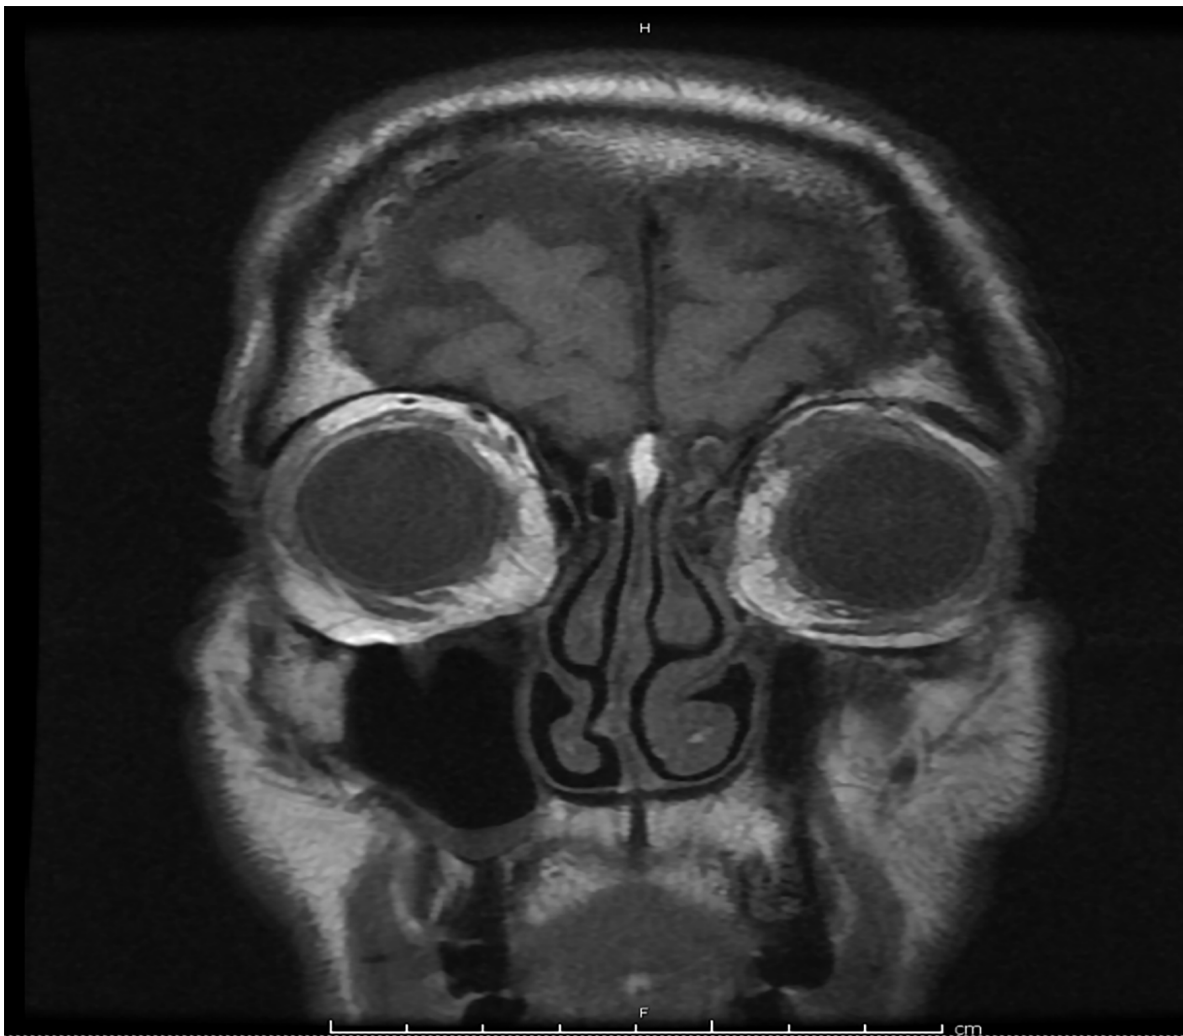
MRI Orbit: Left superior rectus muscles swelling and inflammatory changes on a Coronal T1 fat-sat image.
